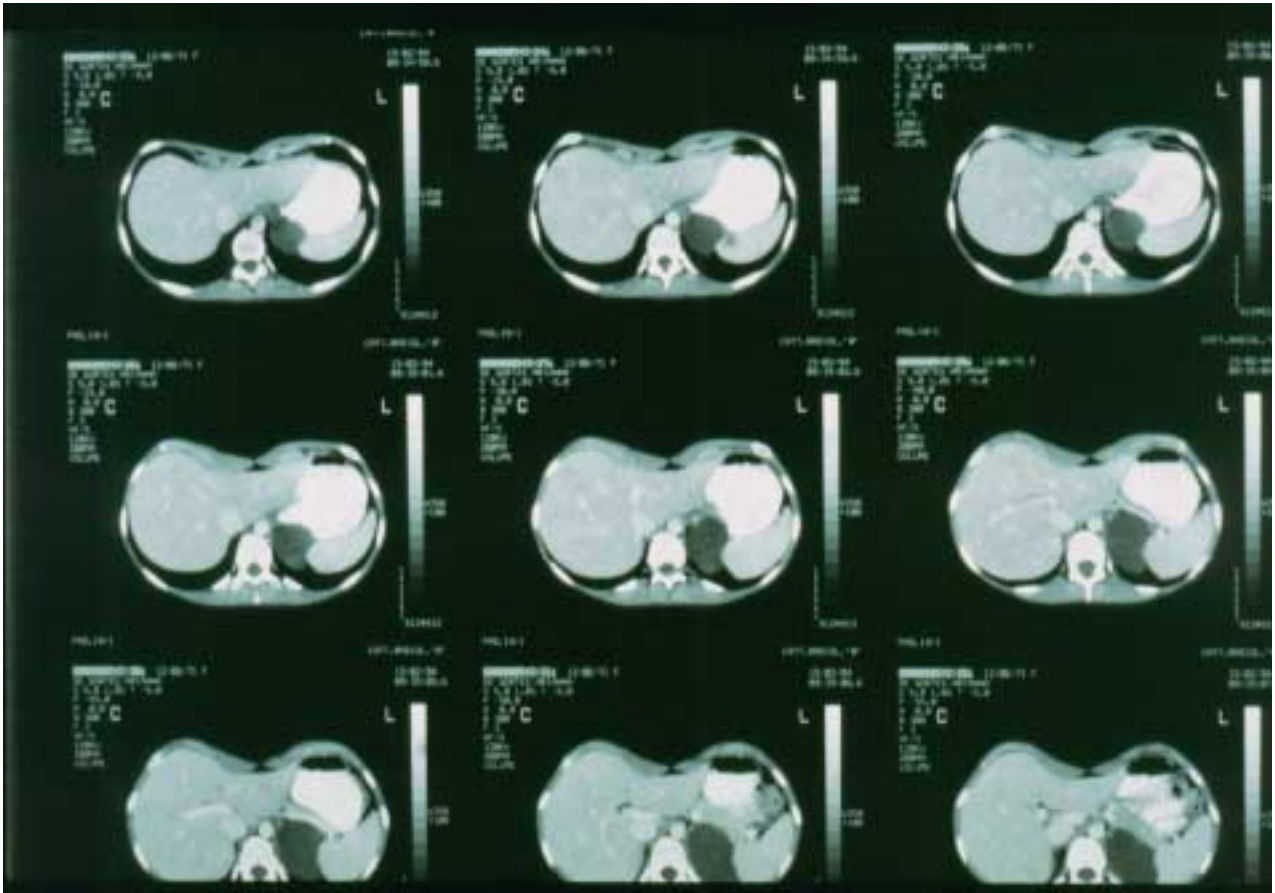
Left adrenal gland cystic neoplasm - CT scan
